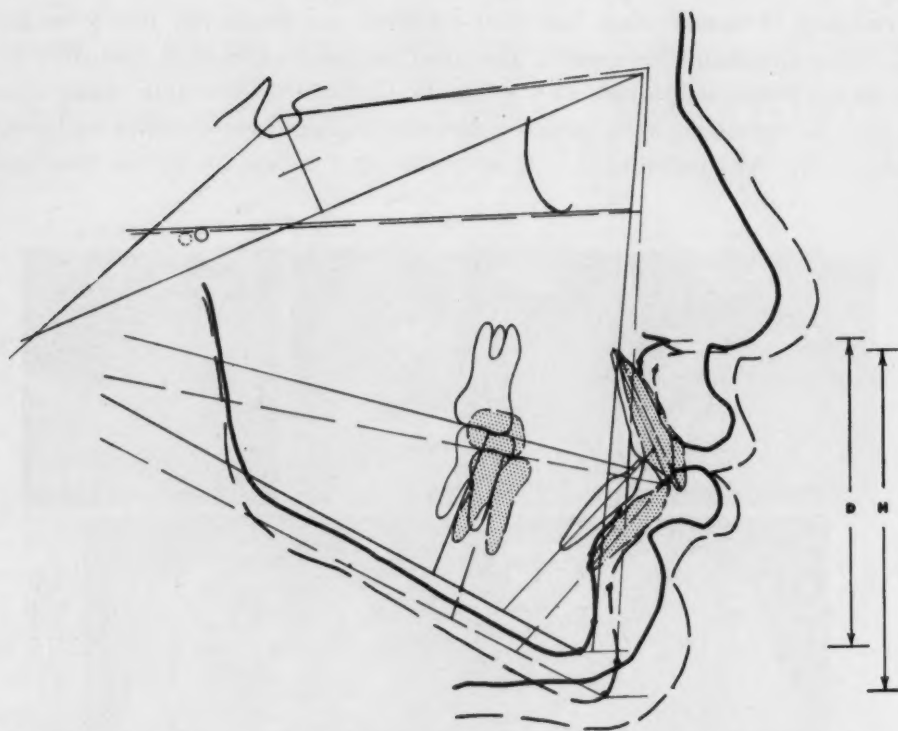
Case 5, Patient T. G. Superposed tracings of cephalometric roentgenograms. Solid line, September, 1950; broken line, February, 1953.
